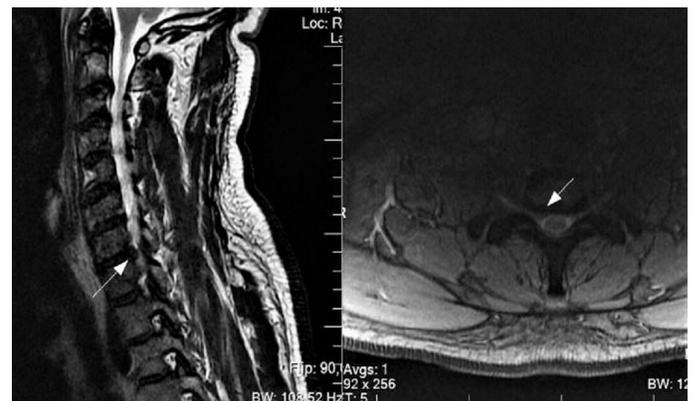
Preoperative cervical MRI showing a disc herniation that narrows the right neural foramina at the C7-T1 level
